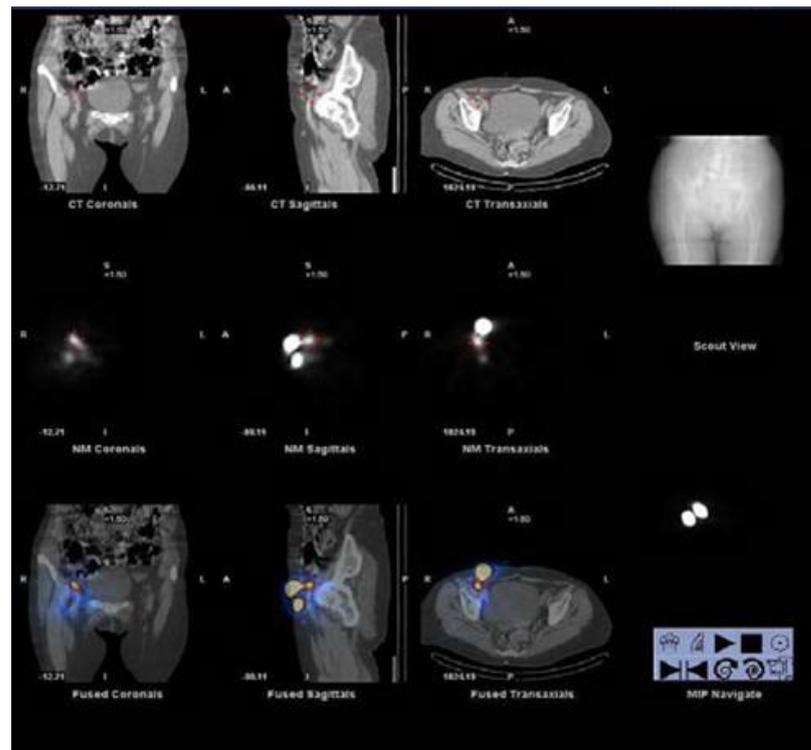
SPET/CT lymphoscintigraphy of the pelvis.
